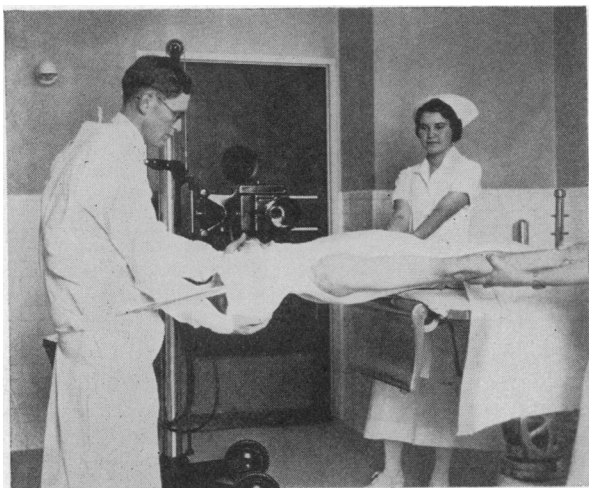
Taylor method of reduction of cervical dislocation. Note the portable x-ray unit.
